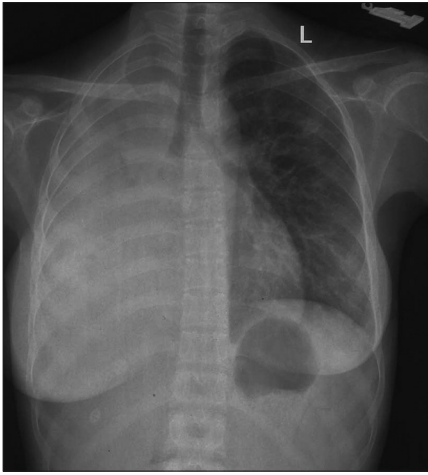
Chest-X-ray revealed the right hemi-opaque lung
